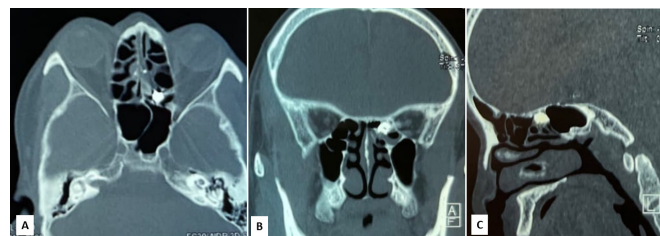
Computed Tomography of nose and paranasal sinus region showing foreign body in left posterior ethmoidal sinus in axial view (A), coronal view (B) and sagittal view (C)
